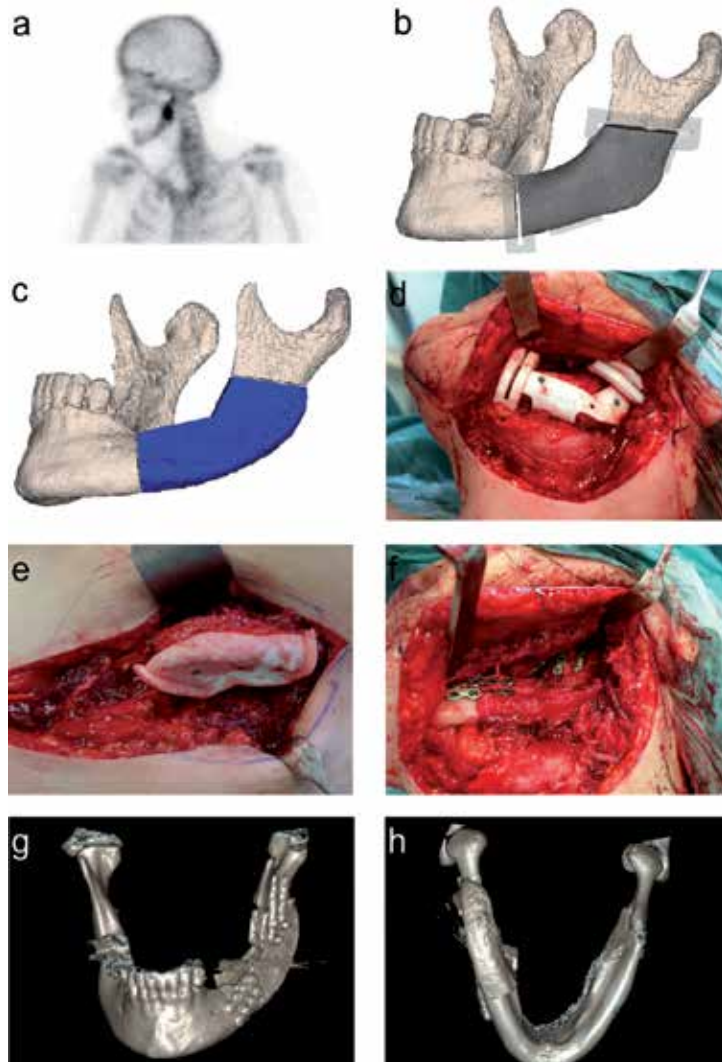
Case 2. (a) SPECT shows osteomyelitis of the left mandible. (b) and (c) Virtual resection and reconstruction of mandible. (d) and (e) Intraoperative positioning of the cutting guides on the mandible and the iliac crest and ASIS. (f) Vascularised iliac bone flap inset and fixed. (g) and (h) Postoperative 3-D CT showing incorporated iliac bone flap.
